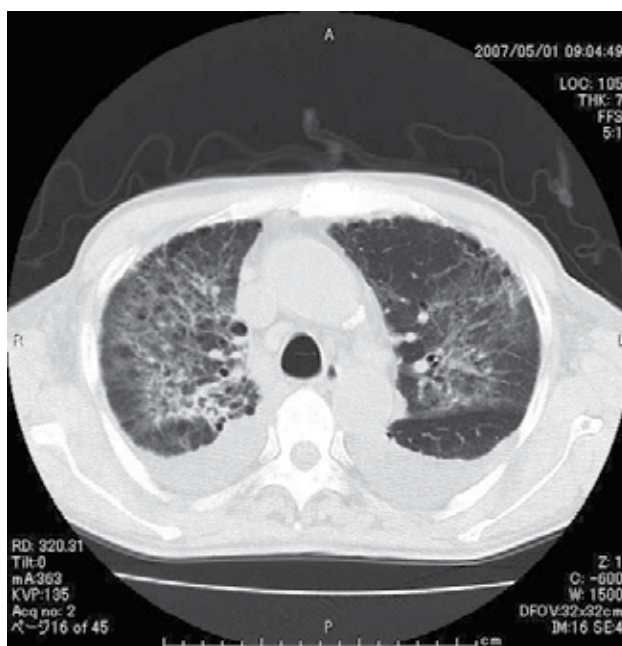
Chest computed tomography in a patient with Goodpasture's syndrome.
